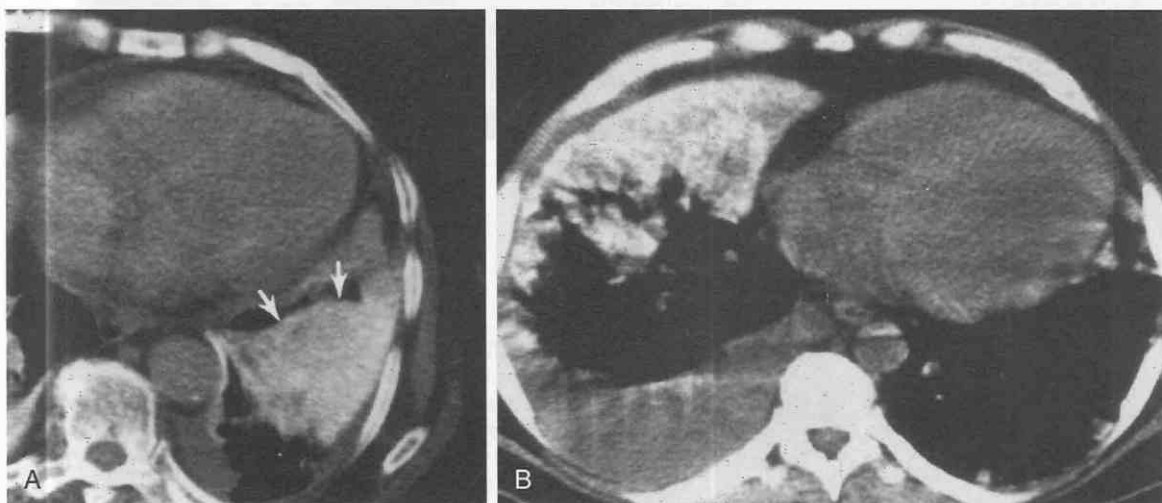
High-density infiltrates on noncontrast CT, differential diagnosis. *A*, High-density atelectatic lung measuring 105 Hounsfield units because of amiodarone toxicity. (From Kuhlman JE, Teigen C, Ken H, et al: Amiodarone pulmonary toxicity: CT findings in symptomatic patients. *Radiology* 177:121-125, 1990.) *B*, High-density consolidation in the right middle lobe in this patient was the result of metastatic pulmonary calcification of chronic renal failure in an area of pneumonia. (From Kuhlman JE, Ren H, Hutchins GM, Fishman EK: Fulminant pulmonary calcification complicating renal transplantation: CT demonstration. *Radiology* 173: 459-460, 1989.)
